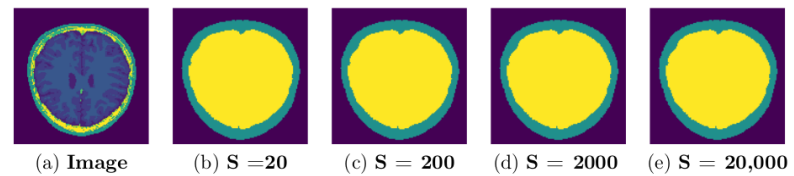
A representative axial section from 3D MRI showing the separation of components for different sample size: MRI from a single subject (BW data set) experimented without threshold, different size of the sampled nodes. GUBS is run on 3D and for visualization we take 2D at the same location for all experiments.
